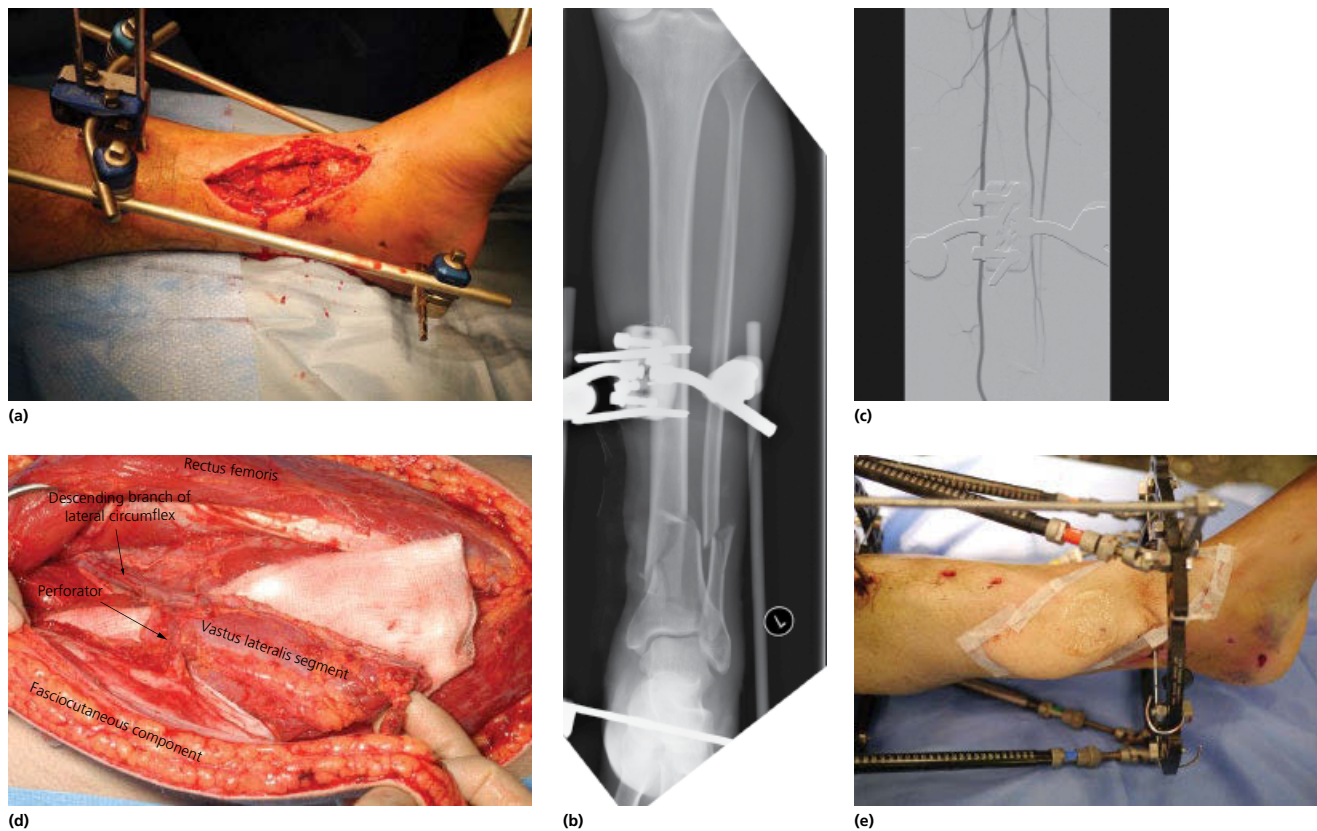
Free anterolateral thigh (ALT) fasciocutaneous flap. (a) Open distal tibial fracture with longitudinal soft tissue defect. (b) Radiograph following BEF showing high-energy fracture pattern. (c) Preoperative angiogram revealing no flow in the anterior tibial and peroneal arteries at the level of the fracture (single vessel leg). (d) Intraoperative photograph of free ALT flap that includes a segment of vastus lateralis. (e) Clinical appearance following coverage with ALT and fracture stabilization with a circular external fixator (Taylor Spatial Frame). Sources: (a, b, c, e) Mr Jon Simmons, FRCS(Plast). Reproduced with permission. (d) Chan et al., 2012.⁷¹ Reproduced with permission of Lippincott, Williams & Wilkins.
